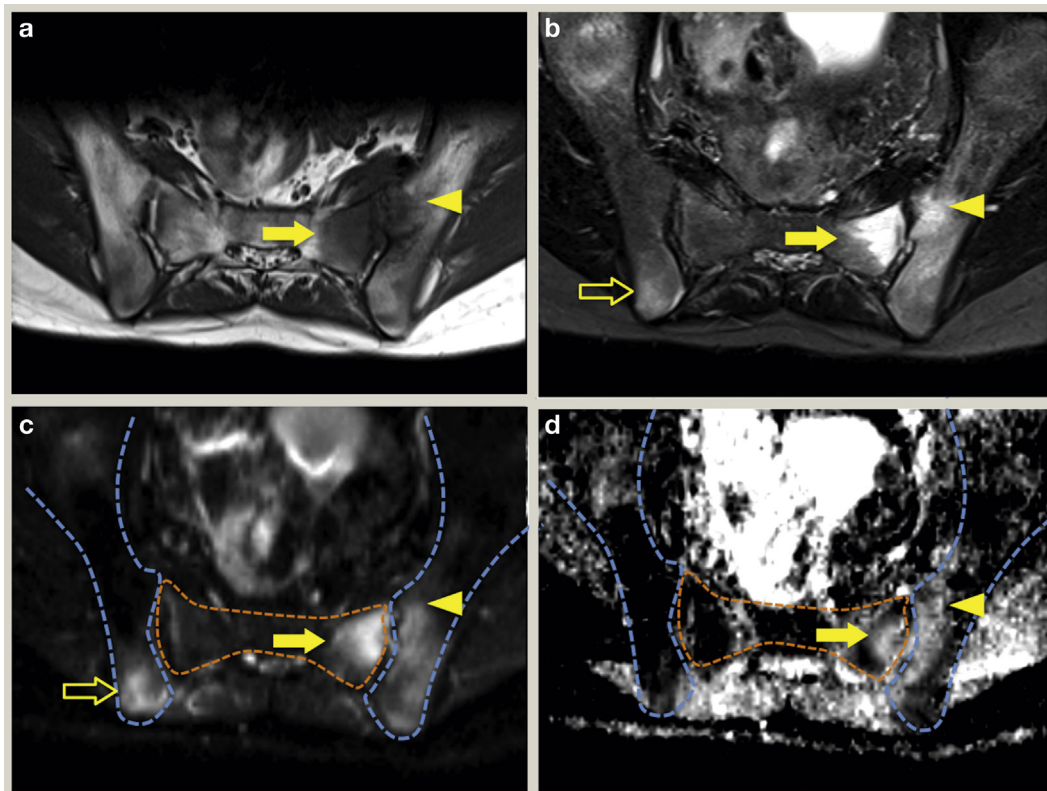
MRI of the sacroiliac joints of a 20-year-old patient with enthesitis-related arthritis and sacroiliitis. There is marked disease of the left joint (arrowhead, iliac side; filled arrow, sacral side), with less extensive involvement on the right (open arrow). (a) T1-weighted image showing subchondral bone marrow oedema/osteitis as low signal intensity, compared with the normal adjacent fatty marrow, which is high signal on T1. (b) Fluid-sensitive STIR sequence demonstrating the corresponding foci of osteitis as high-signal regions. (c) Diffusion-weighted image (DWI) and (d) apparent diffusion coefficient (ADC) map. Areas of active osteitis are hyperintense on both the DWI and ADC images, reflecting unrestricted diffusion (arrowed in (c) and (d)). Blue line, outline of ilium; orange line, outline of sacrum.
